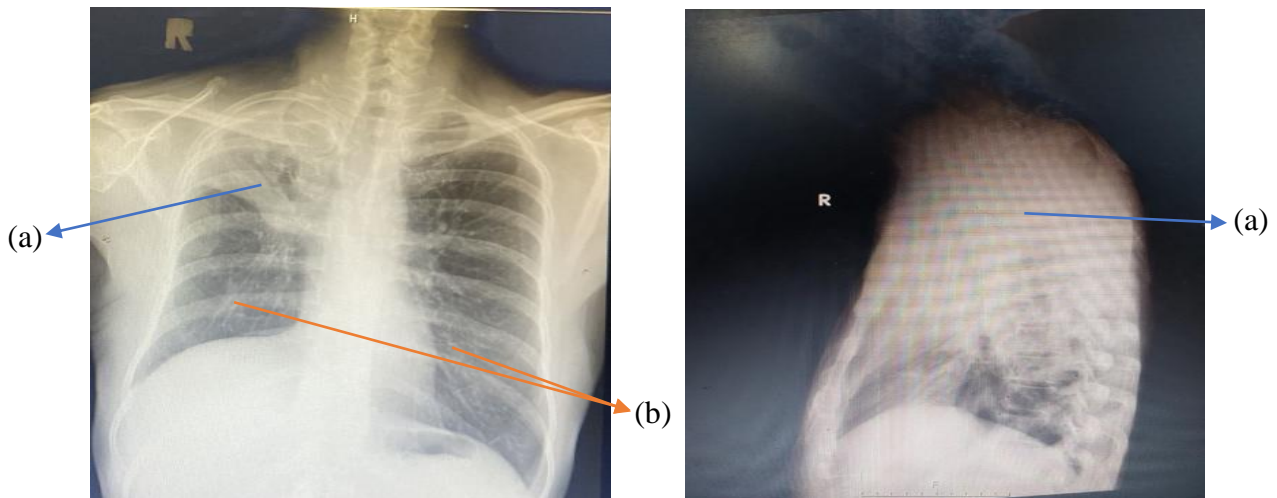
A Chest X-ray serial examination, (a) opacity on the superior lobe of the right hemithorax and (b) Bilateral lung infiltrate
